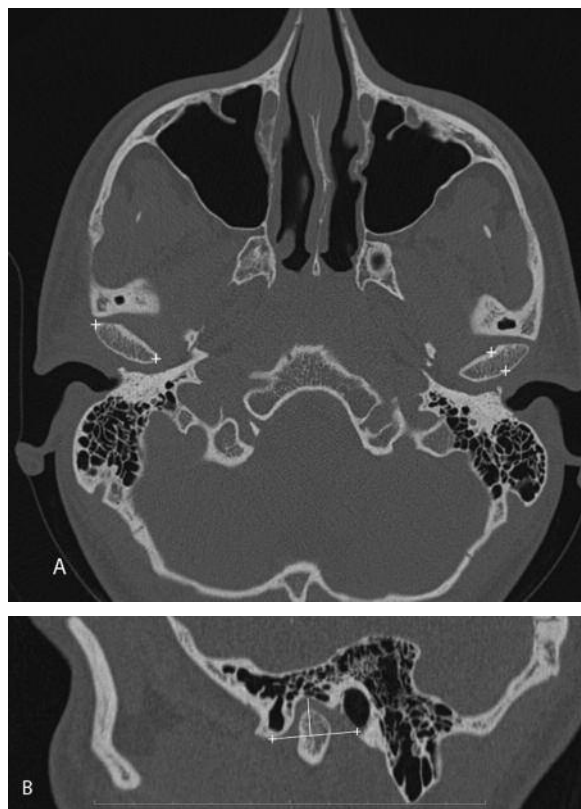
A*, CT images; right, greatest mediolateral diameter of the mandibular condylar process; left, greatest anteroposterior diameter of the mandibular condylar process. *B*, CT images; depth of mandibular fossa.
